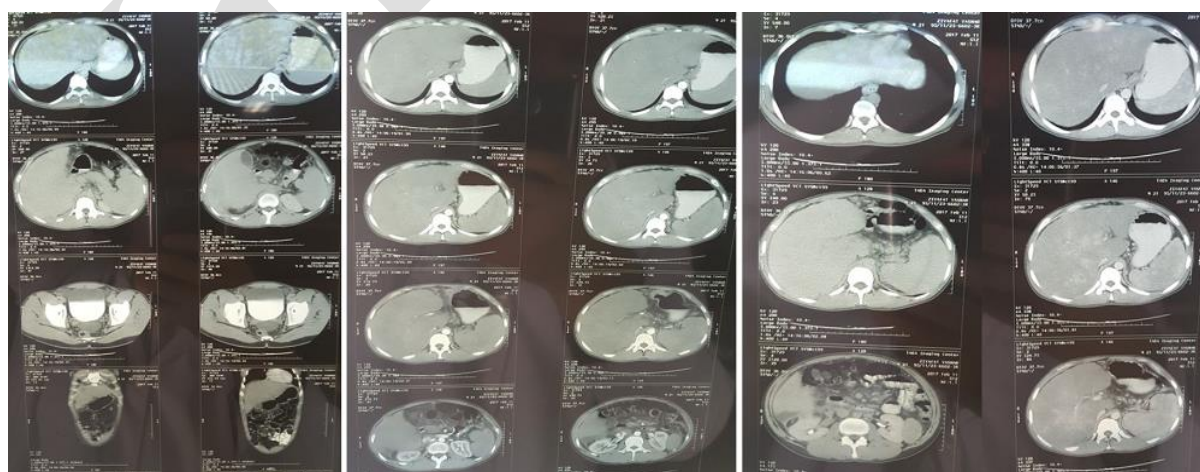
Multidetector spiral CT scan of abdomen and pelvic with IV and oral contrast with coronal and dynamic liver CT images acquisition was performed which showed liver is mildly enlarged with heterogeneous parenchyma. The peripheral part of the liver showed mild hypoattenuation, which is compatible with reverse portal venous blood flow. The hepatic veins could not be well seen. Also, enlargement of the caudate lobe is noted.
